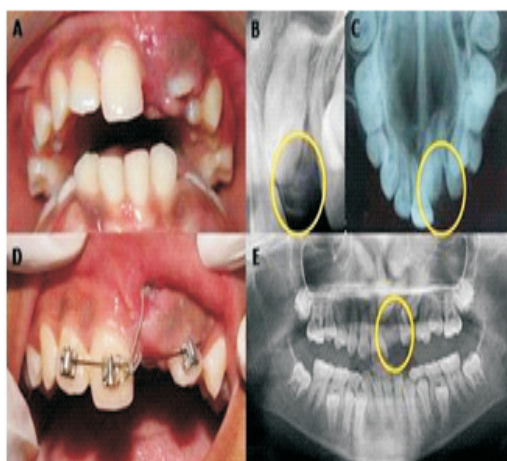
A. Intraoral photograph after one month showing erupting 22. B, C & E. IOPA, occlusal radiograph and OPG to ensure complete enucleation. D. Orthodontic traction after surgical exposure of 21
